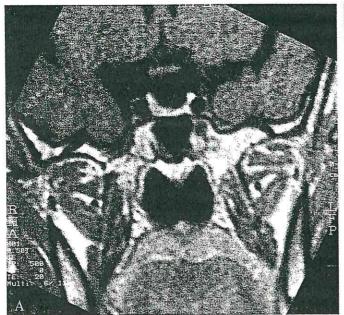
Magnetic resonance (MR) scans in the coronal (A) and sagittal (B) planes, sighted in the sella turcica after gadolinium-enhancement. The MR images show a falciform hypophysis with 3 mm thickness from a 3D acquisition of the whole brain, laying down on the sellar floor with homogeneous contrast-enhancement (CE). Because of the pituitary volume reduction, herniation of the suprasellar cistern in the sellar cavity configures a classical empty sella image. Pituitary peduncle, optic chiasma and third ventricle are normal.
